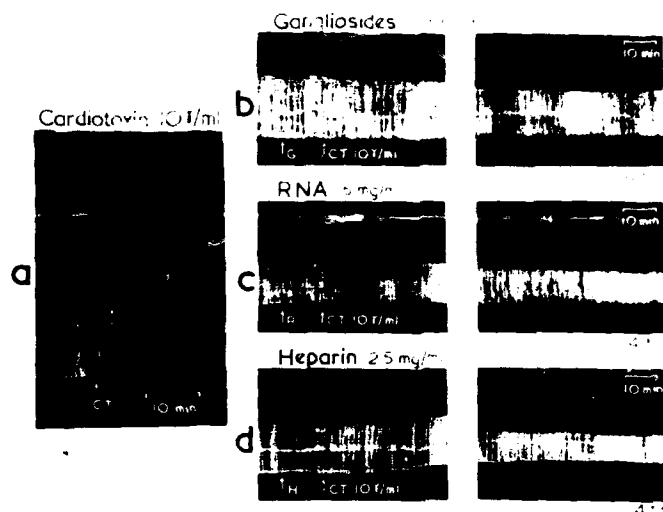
The chick's biventer cervicis muscle. Supramaximal indirect stimulation of 0.5 msec duration was applied at a rate of six per minute. (a) Contracture induced by cardiotoxin (CT) 10 γ /ml; (b) Prevention of contracture by pre-treatment with gangliosides 0.15 mg/ml; (c) with RNA 5 μ g/ml, and (d) with heparin 2.5 mg/ml
